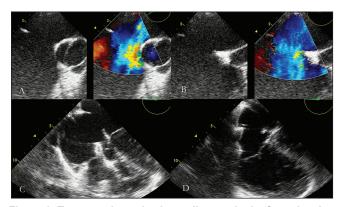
Transesophageal echocardiogram in the four-chamber (a) and short axis view of the aorta (b) showing a large secundum atrial septal defect. The embolized device sat across the tricuspid valve (c) into the RV and was brought into the RA (d) to be reterived by a two snare technique
